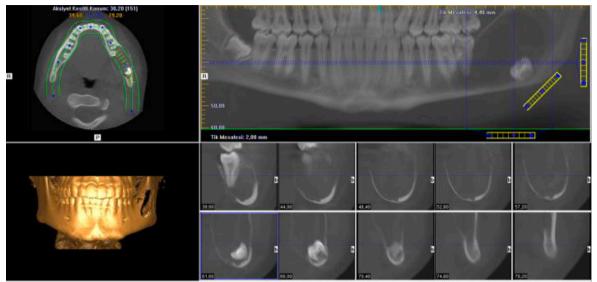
CBCT radiograph of the patient with thin buccal and lingual bone wall.
